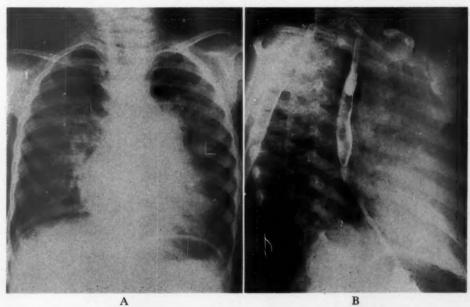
Case 26. Roentgenograms in the posteroanterior (A) and right anterior oblique (B) positions indicating moderate increase in pulmonary vascularity, prominent pulmonary artery trunk, and increased width of right pulmonary artery (pulmonary hypertension) in (A), slight left atrial enlargement (B), and only slight left ventricular enlargement (B).
